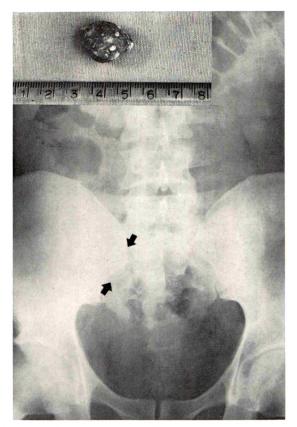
Case v. Supine abdominal roentgenogram showing fecalith overlying the sacrum. *Insert*. Photograph of fecalith recovered from peri-appendiceal abscess.
